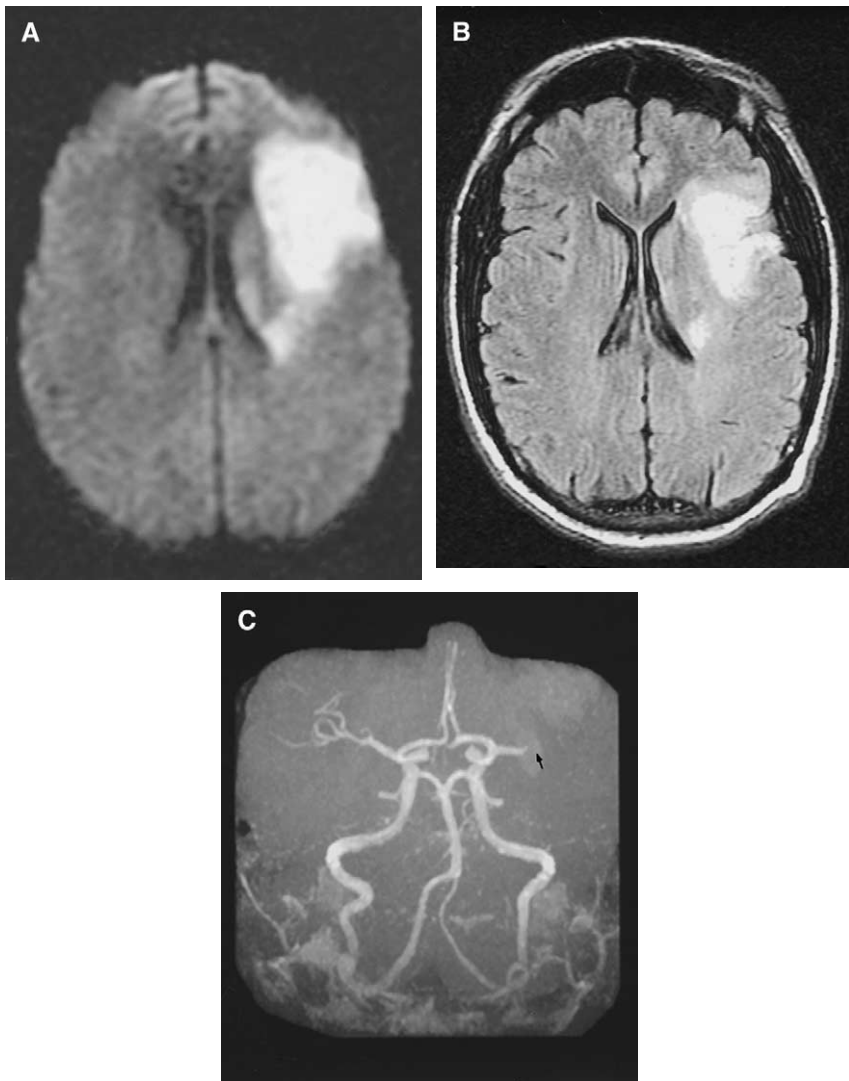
A 29-year-old man with non-Hodgkins lymphoma who received chemotherapy including doxorubicin (adriamycin). Treatment was complicated by the development of a dilated cardiomyopathy with an ejection fraction of 20%. He was not treated with warfarin. Subsequently he presented with right-sided facial and arm weakness and aphasia. MRI showed a large left middle cerebral artery (MCA) stroke. (A) Diffusion MRI showing restricted diffusion, consistent with a stroke, in the left frontal lobe. (B) FLAIR MRI showing the left frontal stroke. (C) Magnetic resonance angiography showing cutoff of the left MCA (suggesting embolus).
